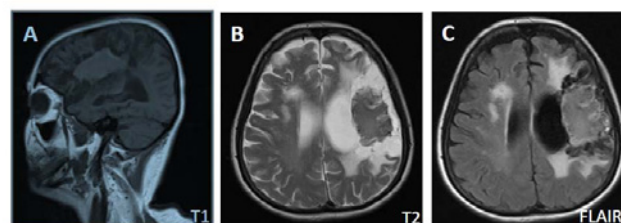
Initial MRI brain demonstrating the old left MCA territory infarct involving the left frontal and parietal lobes associated with encephalomalacia. In the central aspect of this area, there is a lobulated T1 hyperintense (A), T2 (B) and FLAIR (C) hypointense lesion.
